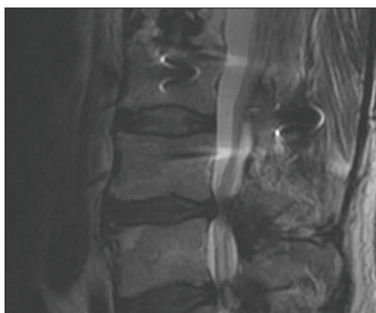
Preoperative sagittal T2-weighted magnetic resonance imaging showing prior L1 surgery and severe spinal stenosis at L3-L4 and L4-L5.
